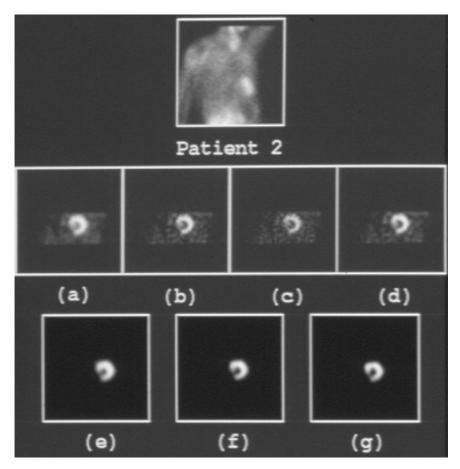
32 show one projection image each of two patients. Transverse SPECT images were reconstructed, and oblique slices perpendicular to the long axis of the heart were then computed from the 3D data available. Figures 10.31 and 10.32 show one representative oblique section image in each case, along with several restored versions of the images. The parts of the myocardium with reduced activity (cold spots) are seen more clearly in the restored images than in the original images. The results of pre-reconstruction restoration applied to the planar images are better than those of post-reconstruction restoration filtering in terms of noise content as well as improvement in sharpness and clarity.
